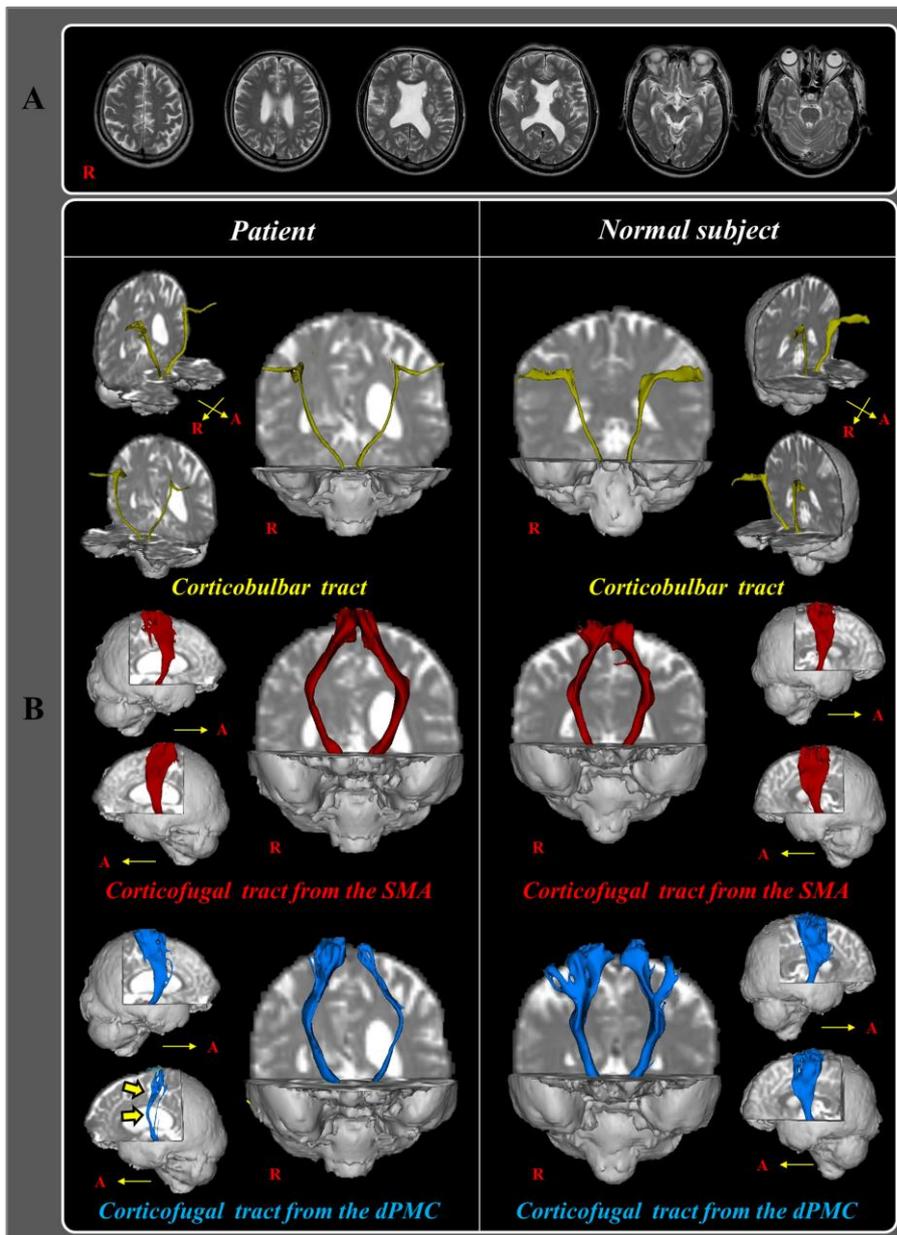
A. T2-weighted brain MR images at a week after onset show leukomalatic lesions in the left striatocapsular region. B. On one-week diffusion tensor tractography, the integrity of the corticobulbar tract and corticofugal tract from the supplementary motor area is preserved in both hemispheres. However, narrowing and tearing (arrow) is observed in the right corticofugal tract from the dorsal premotor cortex (dPMC) compared with a normal subject (56-year old male).
